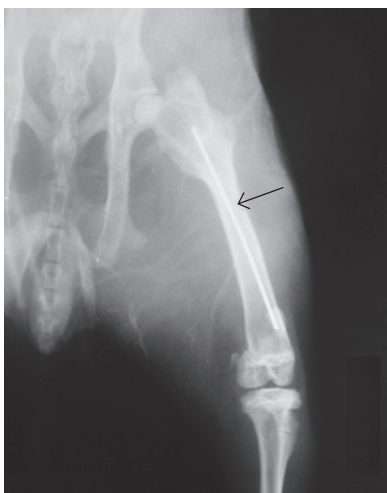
Anteroposterior X-ray image of the operated femur showing an intramedullary Kirschner wire (arrow).
